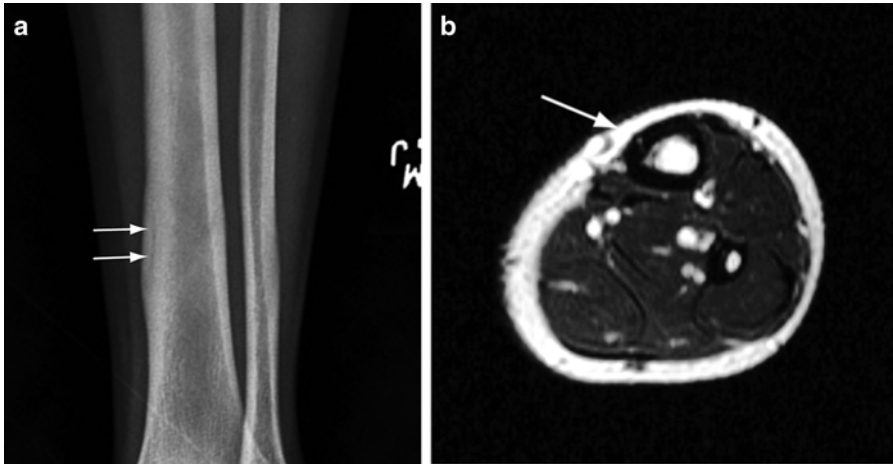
Longitudinal stress fracture. (a) Frontal radiograph of the tibia shows a linear lucency within the thickened medial cortex (*arrows*) in the distal shaft. (b) Axial
